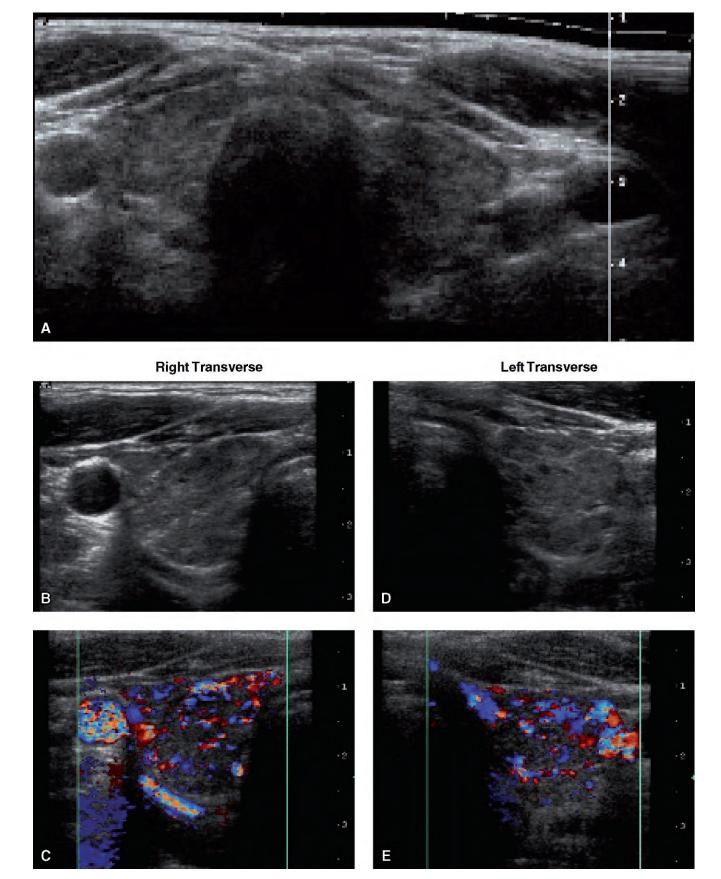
Ultrasound of thyroiditis in both lobes. A, Both lobes. B, Right lobe transverse. C, Color Doppler, right lobe transverse. D, Left lobe Transverse. E, Color Doppler, left lobe transverse.
